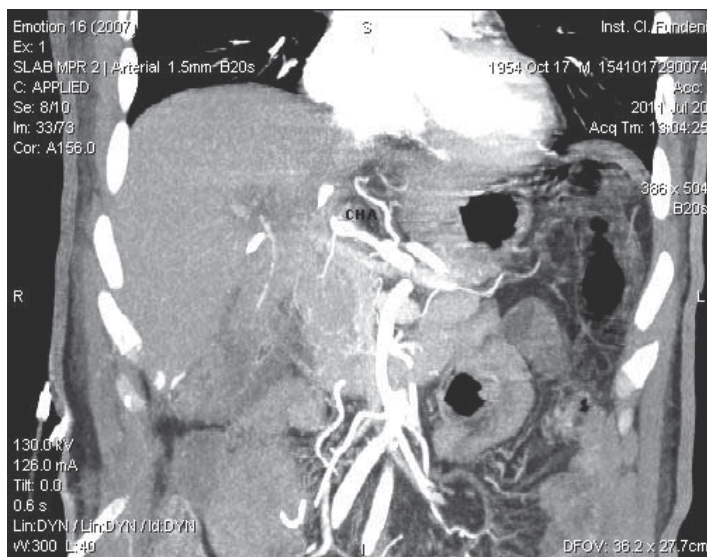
3D CT angiography confirmed complete stenosis of hepatic artery on a patient with right hepatic lobe transplantation
